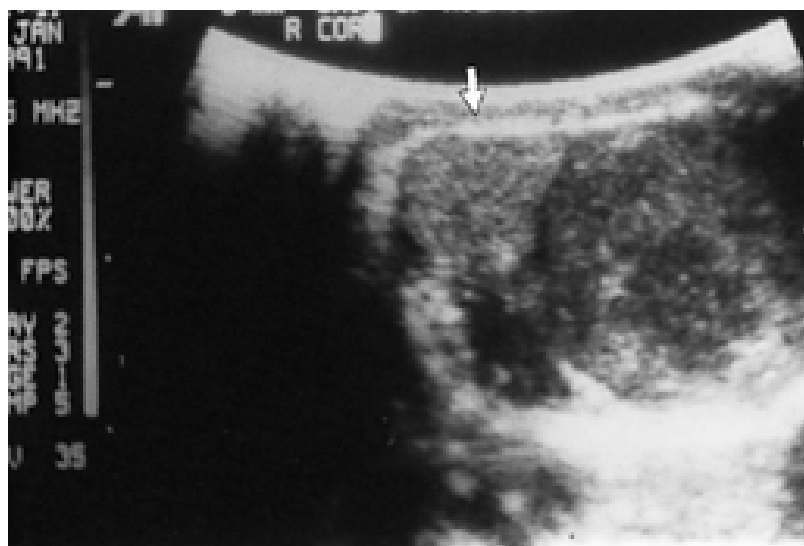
Scrotal ultrasound of a young boy presenting with a painless mass that shows compression of the testicular parenchyma (*arrow*) by the paratesticular rhabdomyosarcoma.
